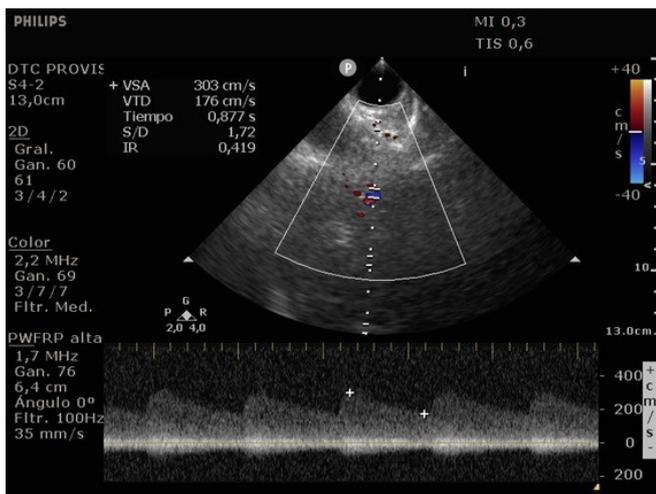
Transorbital ultrasonography.
